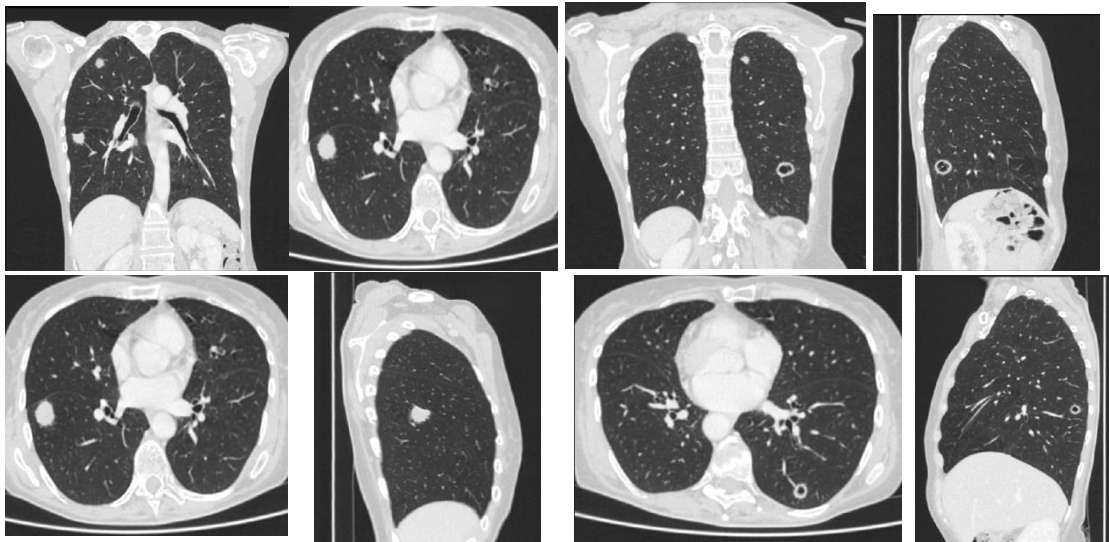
Initial contrast-enhanced chest computed tomography in the axial, coronal and sagittal planes showing multiple nodular and excavated nodular lesions in both lungs: in the apical segment of the upper right lobe 12 mm, in the apicoposterior segment of the upper left lobe 11 mm, in the anterior segment of the upper left lobe 10 mm, in the superior segment of the upper right lobe 20 mm; bilaterally in basal segments one change on each side of the lung was described, measuring 12 mm in the right lung and 20 mm in the left lung
